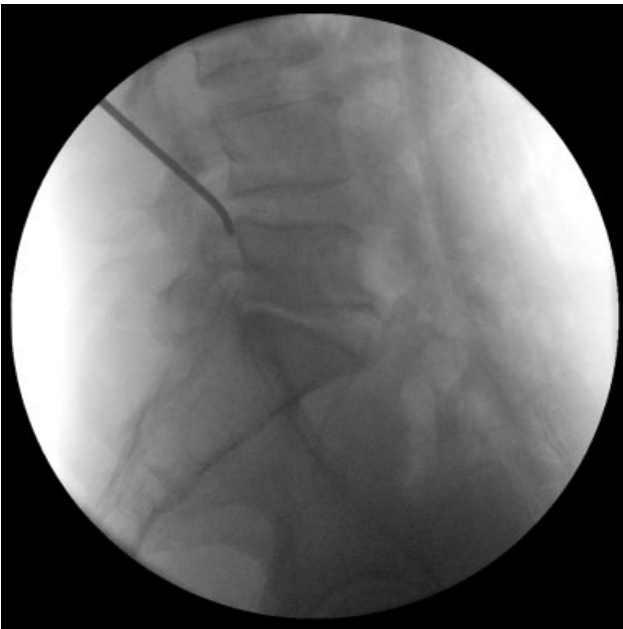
Intraoperative lateral radiographic view after transforaminal insertion of a bent rod into the anterior epidural space at level L4–L5.
